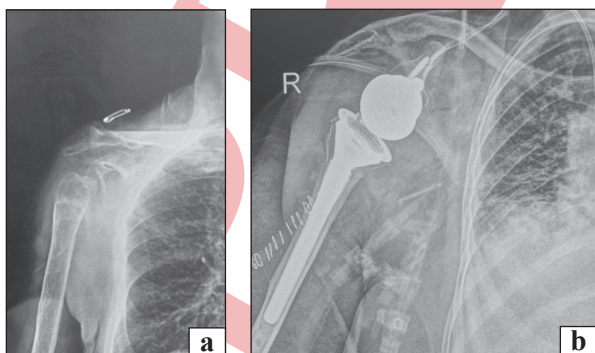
A 55-year-old male patient with a fracture malunion of the anatomical neck of his right humerus: a) preoperative plain radiograph of the fracture; b) postoperative radiograph of reverse total shoulder arthroplasty
